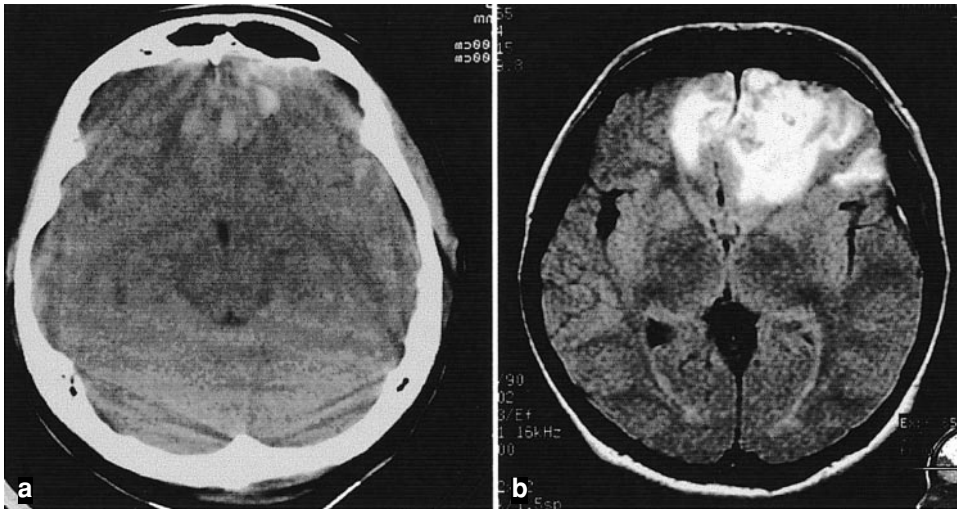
Both CT scan (a) and MR imaging (b) on admission demonstrated bifrontal contusion
